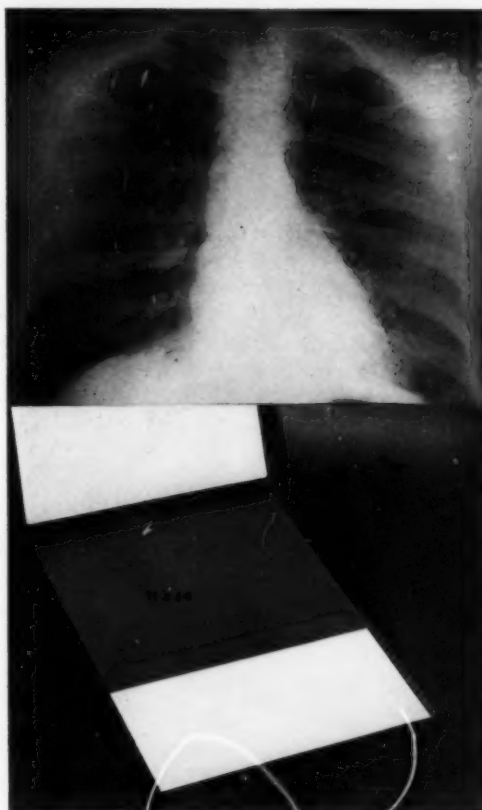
Radiograph of AP lordotic projection on an 11" x 14" film which clearly shows infraclavicular disease but not unnecessary exposure beneath the diaphragm.
